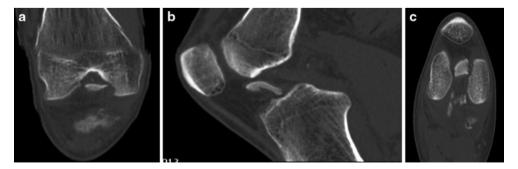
a CT scan—coronal image of a right knee, demonstrating a femoral side PCL avulsion fragment from the medial wall of the lateral wall of the medial femoral condyle. b CT scan—sagittal image of right knee, demonstrating an avulsed fragment of bone within the femoral
